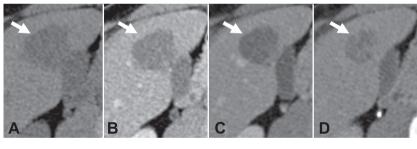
Suspicious hypovascular lesion on dynamic CT. Nodule (arrows) with ill-defined margins, heterogeneity, and contrast enhancement (better appreciated on delayed phase). Lesion was proved to be a colorectal metastasis. Pre-contrast (A), arterial (B), portal-venous (C), and delayed (D) phases of dynamic CT.
